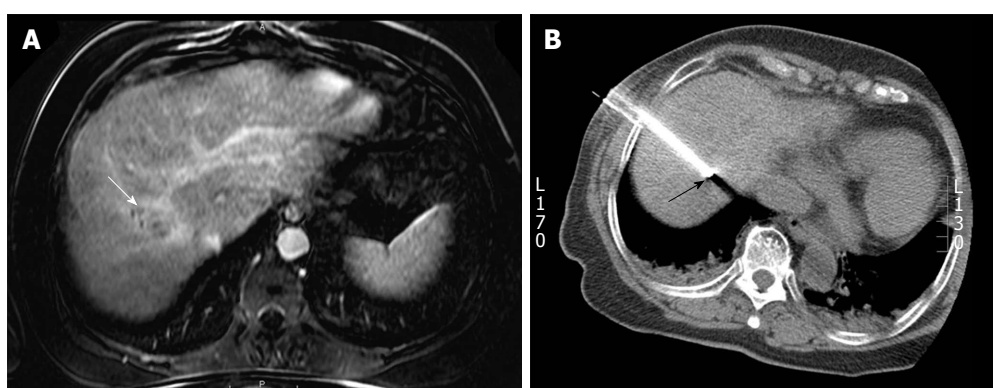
Percutaneous radiofrequency ablation of a hepatic dome hepatocellular carcinoma in a 54-year-old man. A: Axial post gadolinium T1-weighted image in the portal venous phase demonstrates a 3.4 cm hepatocellular carcinoma in the hepatic dome (arrow); B: During the radiofrequency ablation procedure, the patient was placed in the oblique position and using a lateral intercostal approach the tumor was accessed for a successful ablation (arrow).
